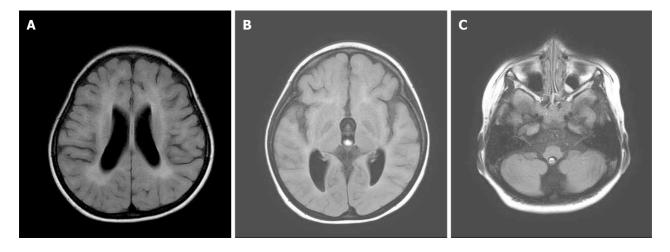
Magnetic resonance imaging of the brain without contrast medium. A: Axial T2 FLAIR, leukodystrophy at the frontal subcortical and periventricular regions accompanied by a decreased amount of white matter; B and C: Axial T2 FLAIR, atrophic bilateral thalami, brain stem, and cerebellar hemispheres.
